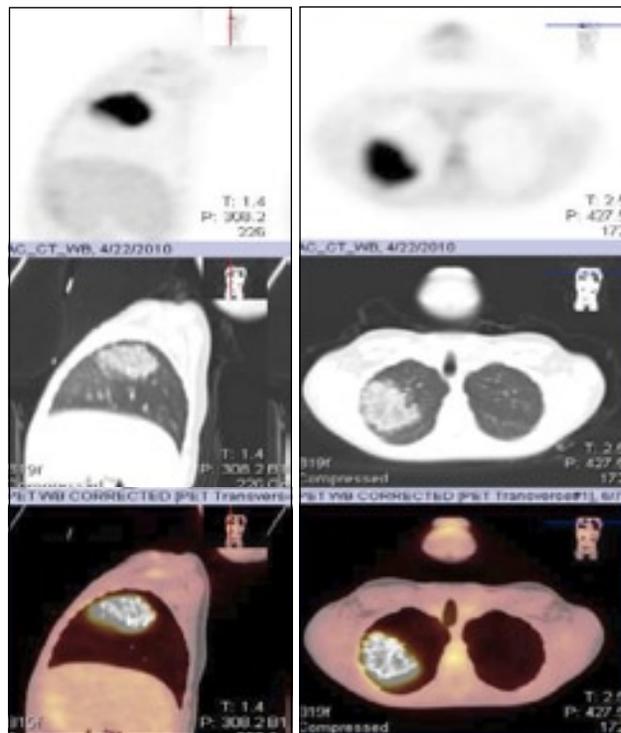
Transverse and axial views ¹⁸F-FDG PET/CT of patient with consolidation and positive ¹⁸F-FDG uptake in the right upper lobe (arrows).
